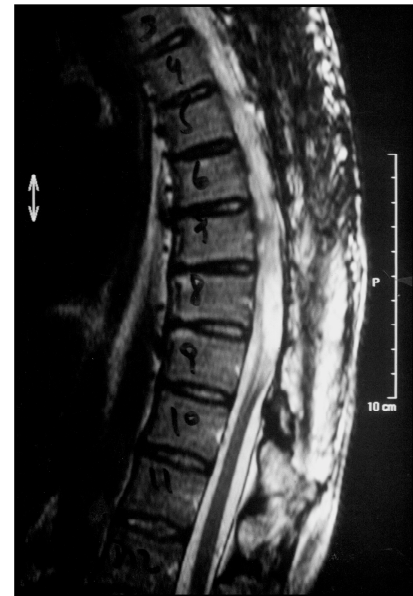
MRI shows the presence of a tumor at the T6 level, and an arachnoid cyst of T7 to T9.
